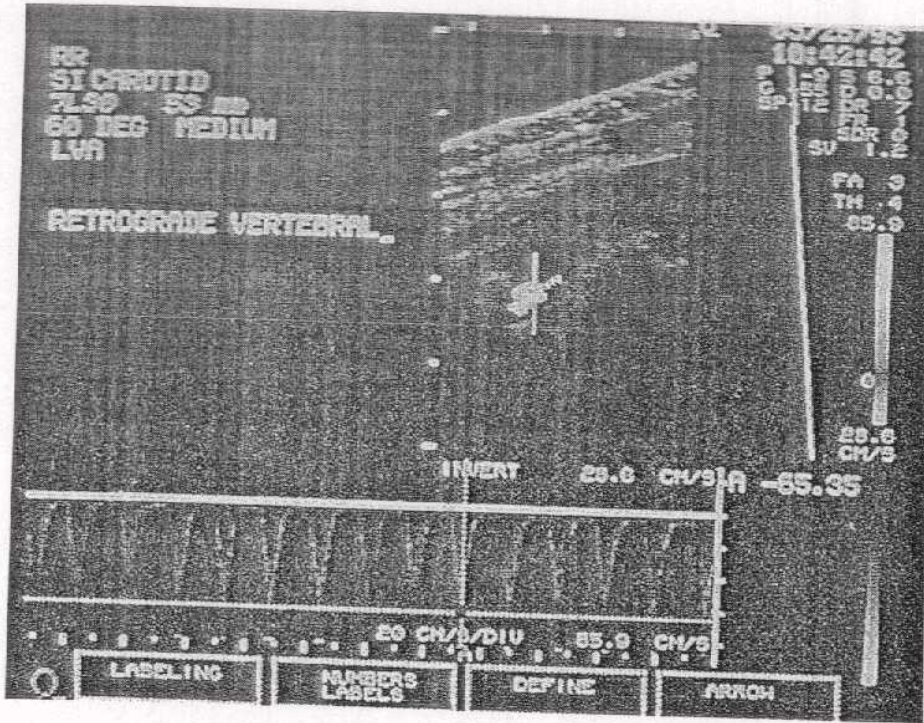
Vertebral arteries in left subclavian steal. B) Fully retrograde Doppler flow signal in the left vertebral artery. Note that the flow is below baseline with negative velocity reading. (Quoted from *Diagnostic Ultrasound*, 1998).
